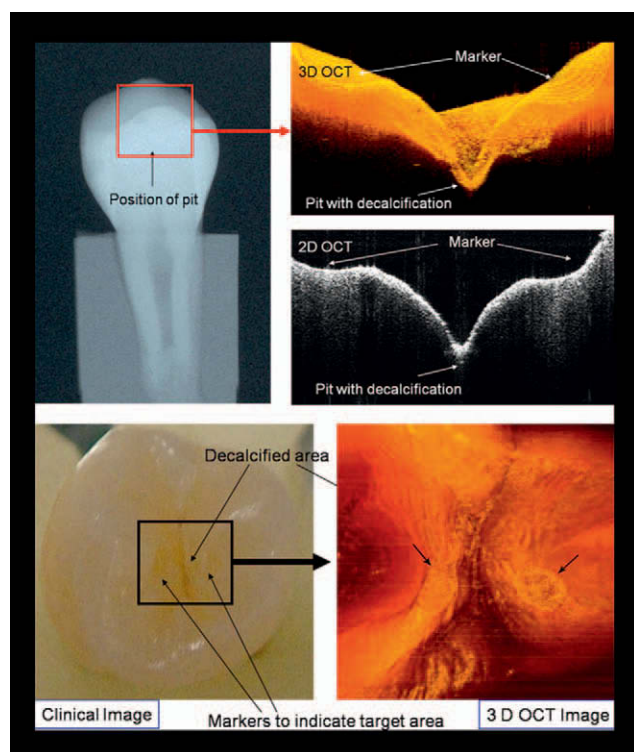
• Two-dimensional (2D) and three-dimensional (3D) OCT images with clinical intraoral and x-ray comparisons. (Courtesy Dr. Petra Wilder-Smith.)
